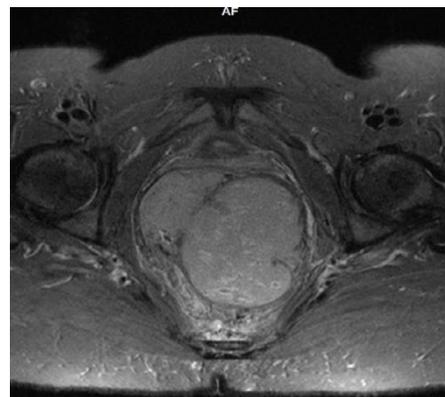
Axial T2-weighted MRI Pelvis
